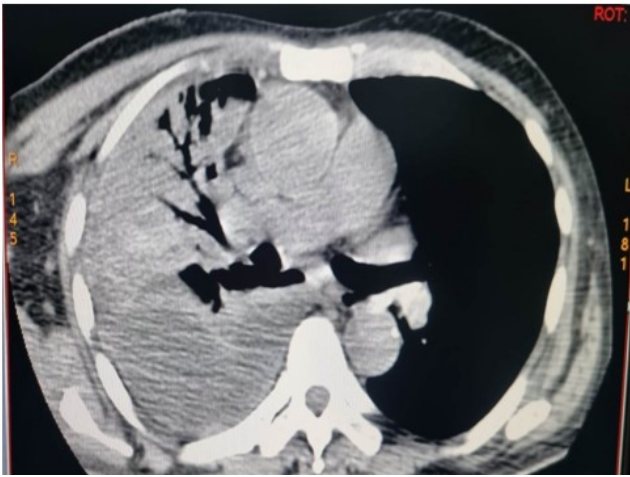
Diffuse right upper lobe consolidation seen on HRCT
